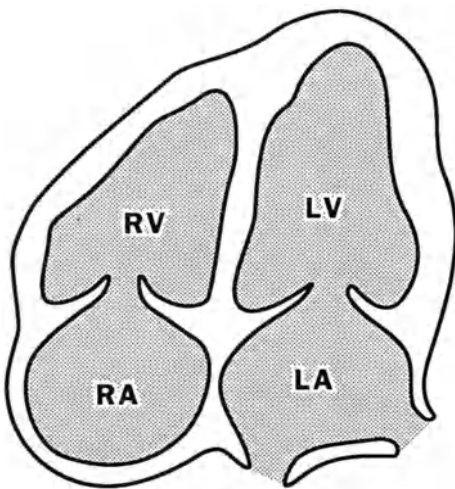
2D Echocardiogram: Apical four chamber view.
